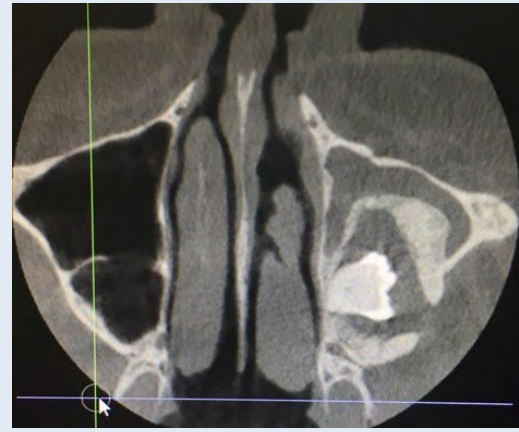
CBCT axial view: bony window showing centrally positioned wisdom tooth surrounded by radiopaque rim within maxillary sinus. Fluid level appreciated in maxillary sinus.
